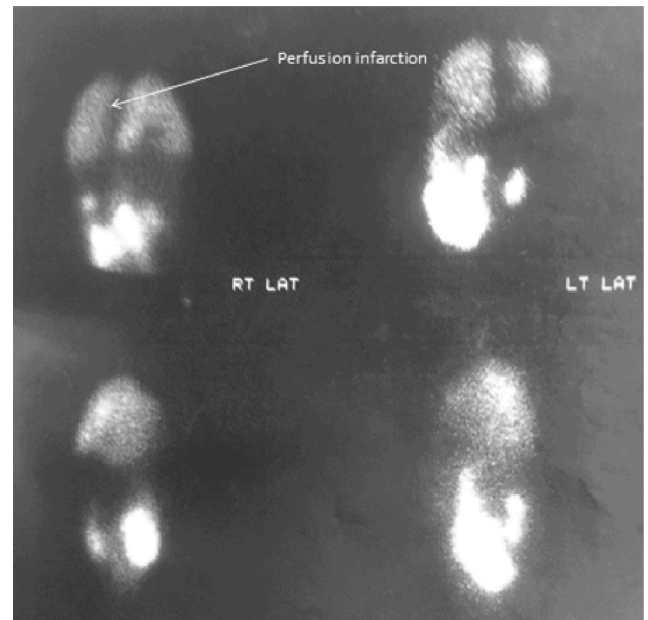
Pulmonary ventilation - perfusion scintigraphy reveals perfusion defects in right upper lobe apical segment and posterolateral aspect of lower lobe due to pulmonary infarction resulting from dislodged vegetations .
